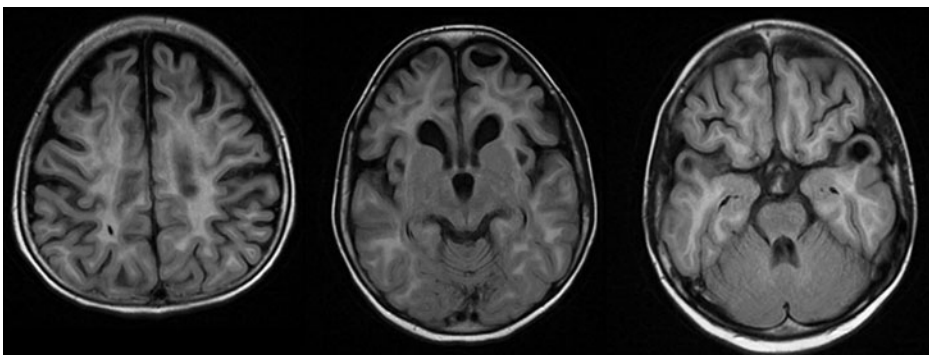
A 7 year-old girl with megalencephalic leukoencephalopathy with subcortical cysts. FLAIR sequence from the brain MRI shows diffusely abnormal cerebral white matter with relative preservation of the brainstem, mildly abnormal cerebellar white matter and primarily anterior temporal and frontoparietal cysts along with cerebral atrophy. Courtesy of Jayne Ness, MD, PhD, The University of Alabama at Birmingham.
